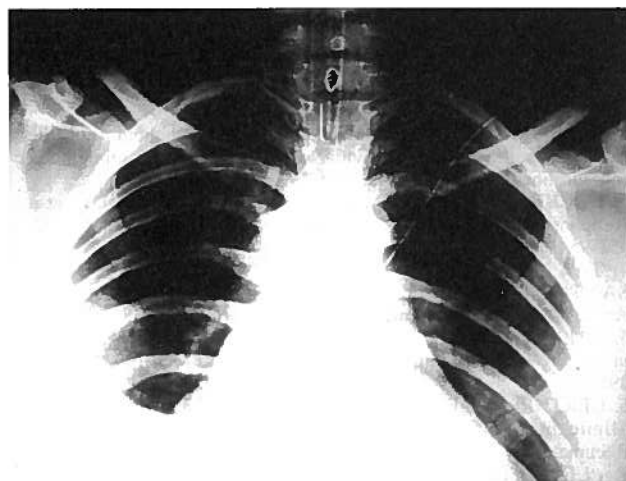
Chest X-ray: triangle shaped opacity in the middle of the right lung field
